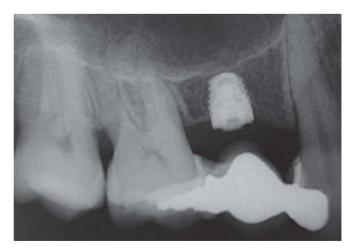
Periapical radiograph 5 months after implant installation surgery.
